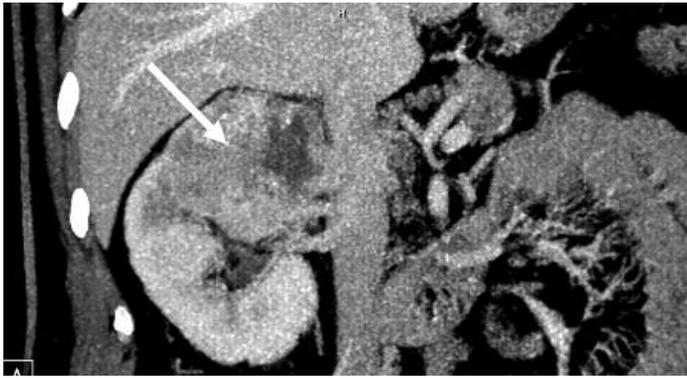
Right renal primary on CTA- Case 1
